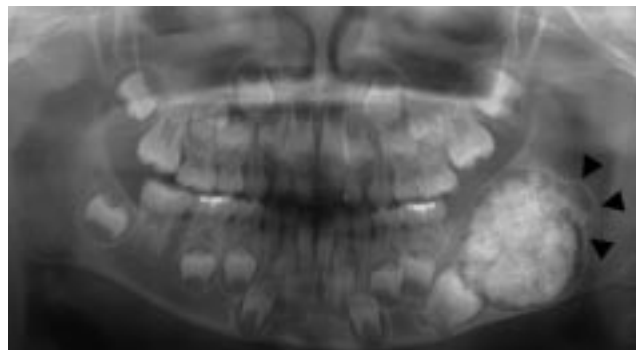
Panoramic radiographic examination showing a large lesion in the body of the left mandible. Dental impaction of the first deciduous molar of the left mandible was identified and displacement due to the compressive pathological lesion in the centrifugal region of the second deciduous molar of the left mandible confirmed (arrowheads).
